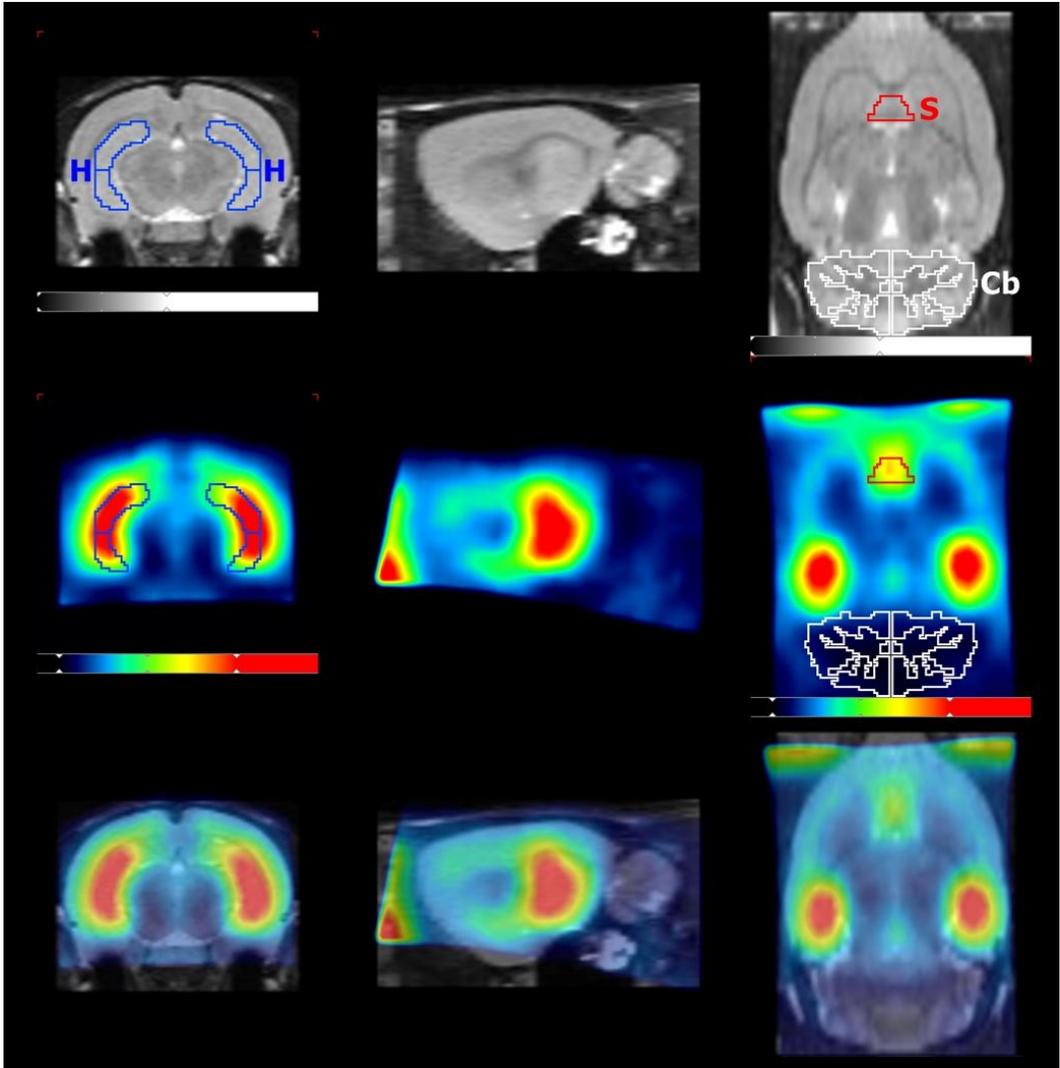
Predefined volumes of interest for time–activity curves and quantitative analyses. PET images were spatially co-registered to the T2-weighted magnetic resonance imaging template. Predefined volumes of interest of the septum, hippocampus, and cerebellum were overlaid on the time-averaged dynamic PET data (20–60 min) for time-activity curves and for quantitative analyses. H, hippocampus; S, septum; Cb, cerebellum.
